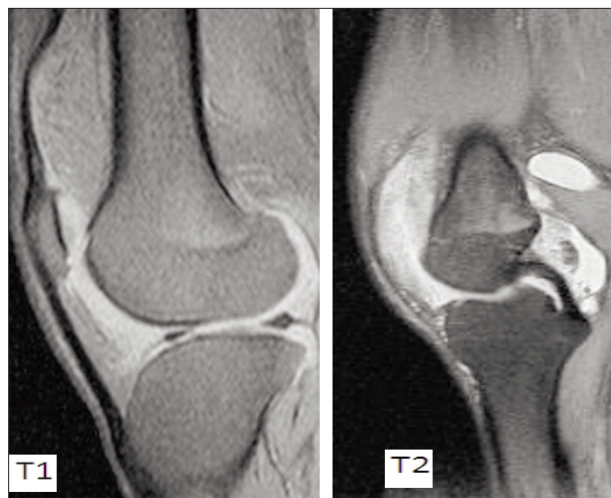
MRI : sagittal T1 and T2- weighted images and after fat suppression
